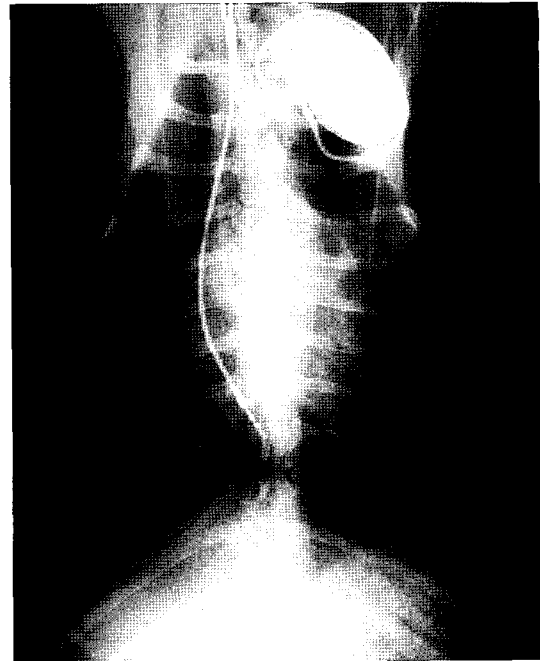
Thoracic radiography showed revealed proper positioning of the leadwire (CAPSUREFIX[®] NOVOUS 5076, Medtronic, USA) and pulse generator (Kappa KSR903, Medtronic, USA).
